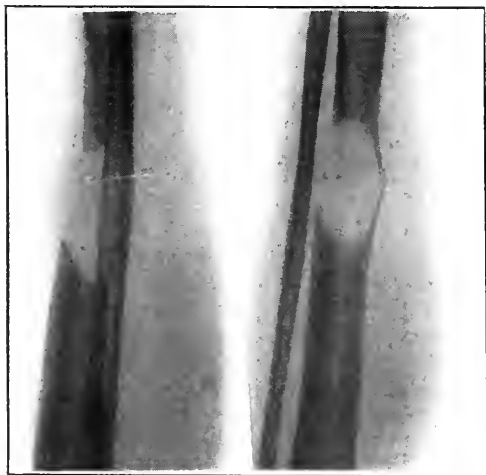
Radiograph showing the spontaneous fracture of the tibia due to the tumour.
